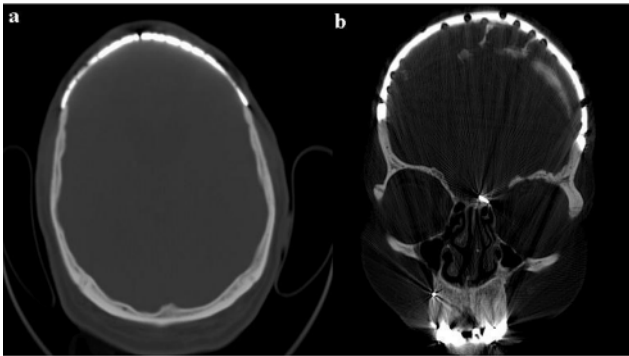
Axial (a) and coronal (b) CT reconstructions obtained in a 62-year-old patient with the history of a severe head injury and fronto-basal fractures with a subsequent infection of the bifrontal bone flap.
